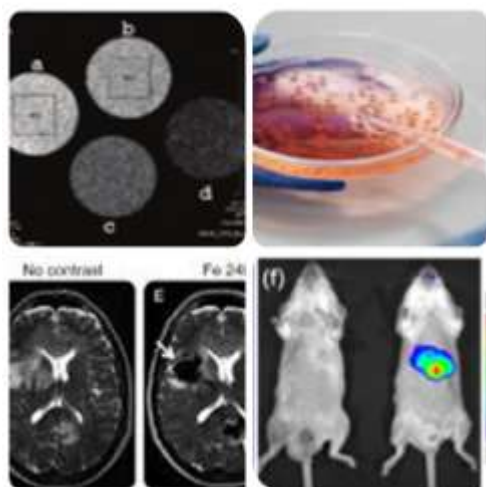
images MRI diagnostic of GBCA and IO-NPs in vitro and vivo.
